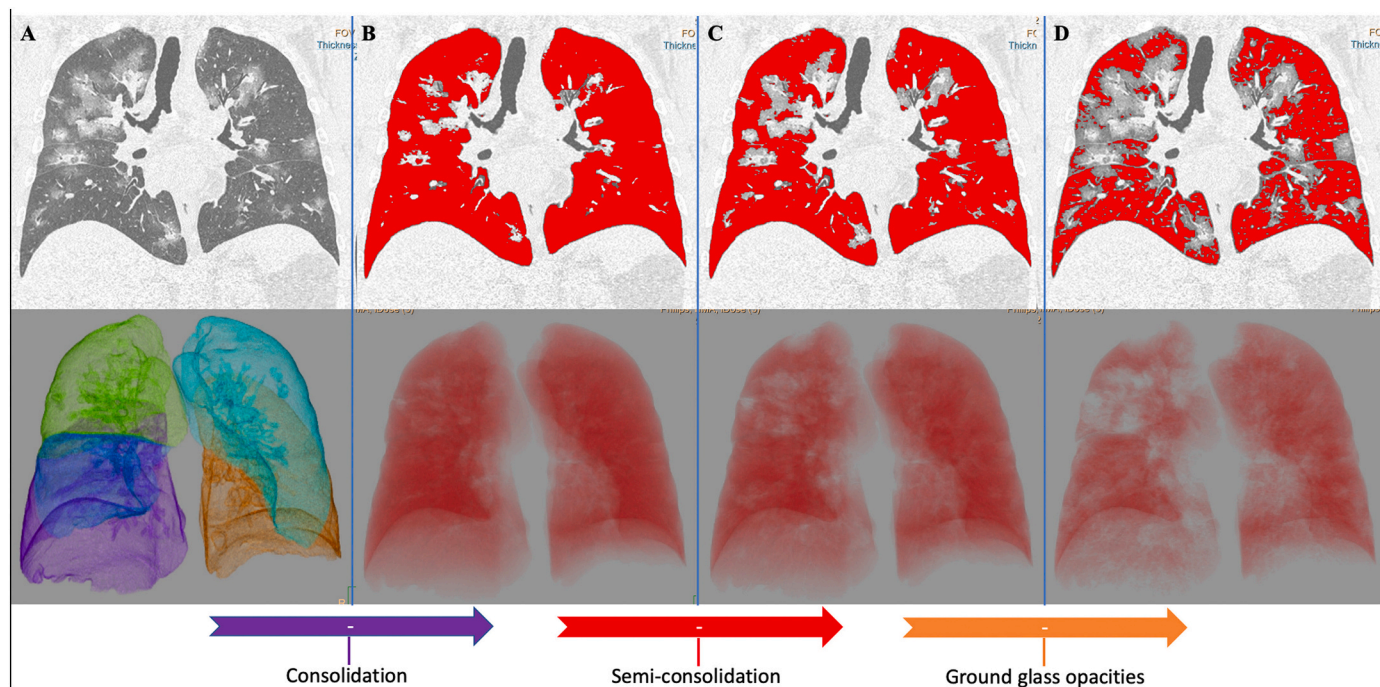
Automatic segmentation of both lungs with quantitative extraction of well-aerated parenchyma, ground glass opacities, semi-consolidation and consolidation. This figure reports the coronal images (on top) and the corresponding 3D volume rendering (bottom), obtained during post-processing performed using a dedicated software (IntelliSpace Portal v.8.0, Philips Medical Systems, Eindhoven, The Netherlands). The software performs a fully automatic segmentation of both lungs from native CT dataset (A). After visual check and manual correction of any segmentation error, the HU thresholds calculated as in Fig. 2 were applied in a multistep fashion analysis. In the first step (B) consolidation pattern was extracted from total lung volume applying the threshold -290HU. In the second step (C) consolidation plus semi-consolidation were extracted from total lung volume applying the threshold -570HU. In the final step (D) consolidation, semi-consolidation and ground glass opacities were extracted from total lung volume applying the threshold -780HU and the red volume (D) represent the well-aerated parenchyma. Hence, consolidation volume was obtained subtracting red volume in B from total lung volume (A); semi-consolidation volume was obtained subtracting red volume in C from red volume in B; ground glass volume was obtained subtracting red volume in D from red volume in C. (For interpretation of the references to color in this figure legend, the reader is referred to the web version of this article.)
